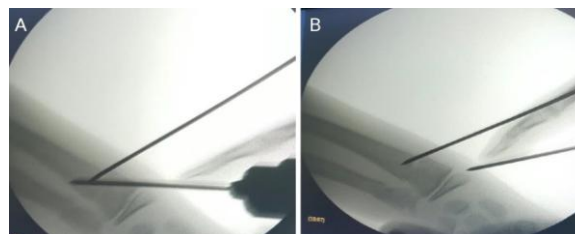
An x-ray in which the reduction of the proximal (A) and distal fragment (B) of the fracture was made using Sommer - pins
